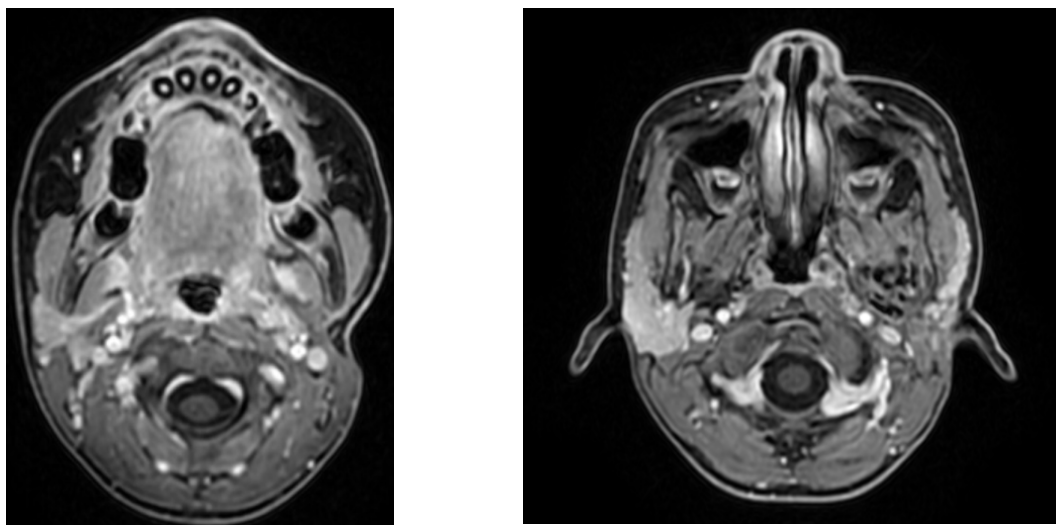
The MRI imaging after two months of radiotherapy
